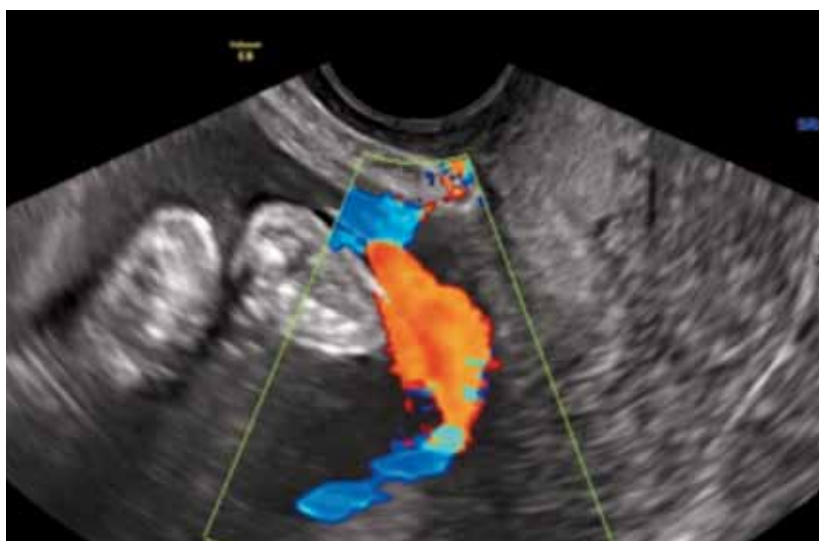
Transvaginal ultrasound with color Doppler in sagittal plane showing the fetal vessels running cross the internal cervical os.
